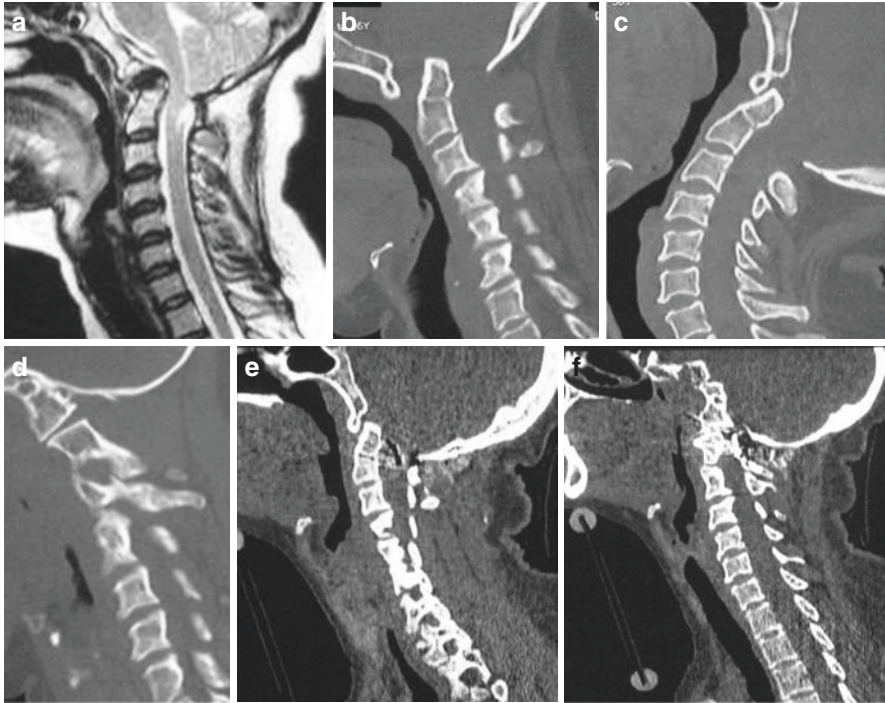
Images of a 23-year-old male patient showing mobile atlantoaxial dislocation in a case with basilar invagination. (a) T2-weighted MRI image showing basilar invagination, assimilation of atlas, Chiari formation, and cord compression. (b) CT scan with the head in flexed position showing basilar invagination in the form of vertical or superior migration of the odontoid. (c) CT scan with the head in extension showing reduction of the dislocation. (d) CT scan cut through the facets showing assimilation of atlas and no significant malalignment. (e) Postoperative CT scan showing realignment of the craniovertebral junction. (f) Postoperative image through the facets showing lateral mass plate and screw fixation
